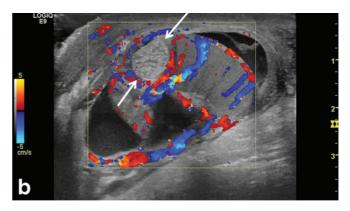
Torsed testicular appendage (white arrows). It is >5 mm, spherical in shape, echogenic, has increased periappendiceal blood flow, and has no blood flow within the torsed appendage. Adapted from Figure 8b of Bandarkar AN, Blask AR. Testicular torsion with preserved flow: key sonographic features and value-added approach to diagnosis. *Pediatr Radiol.* 2018;48(5):735–744. doi:10.1007/s00247-018-4093-0.
